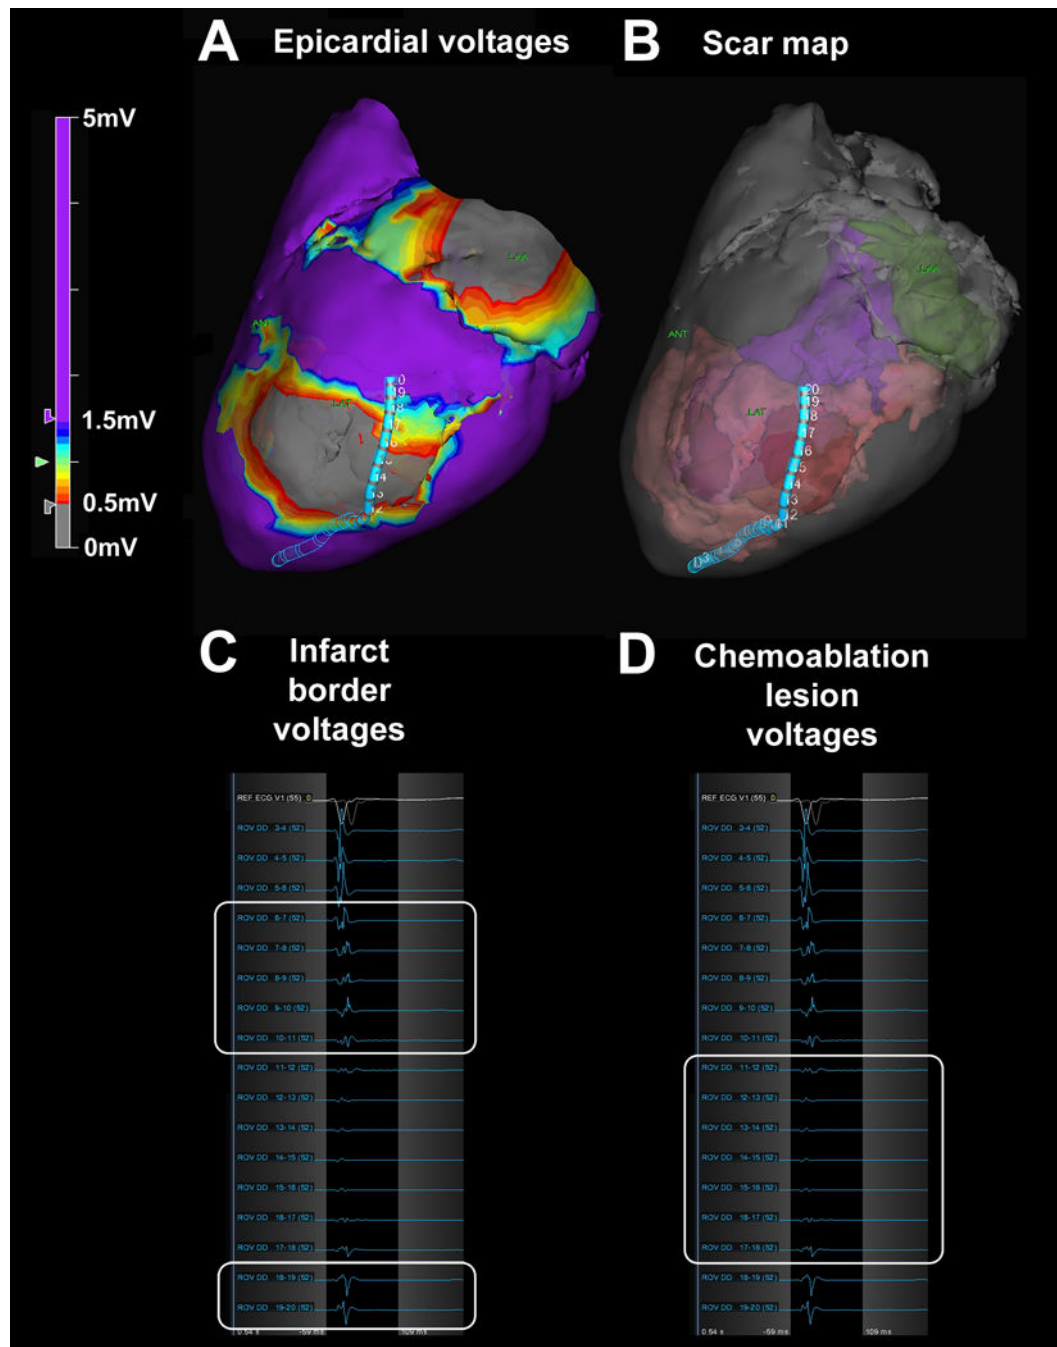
Scar border geometry. (A) Epicardial voltage map showing the duo-decapolar mapping catheter spanning the chemoablation lesion. (B) Three-dimensional scar map derived from high-resolution ex-vivo MRI showing catheter position relative to pre-existing infarct (pink) and chemoablation lesion (red). The left ventricular cavity appears in purple and the left atrium in green. (C) Pre-existing infarct borders (white boxes) have low voltages (0.5–1.5mV), and (D) chemoablation lesion (white box) has extremely low voltages (<0.5mV).
